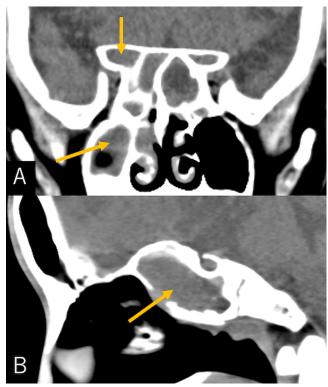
Noncontrast coronal (A) and midsagittal (B) computed tomography at the initial presentation showing findings of sinusitis in the maxillary sinus, sphenoid sinus, and unusually developed aeration formed in the anterior clinoid process (arrow).
